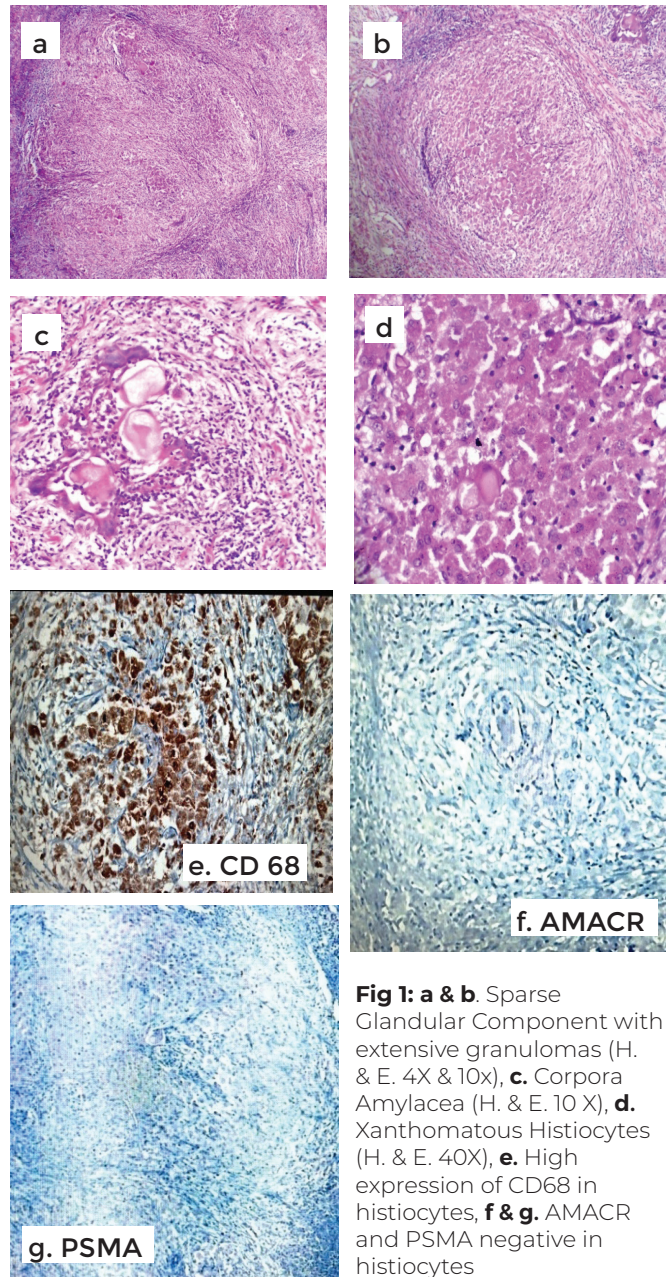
a & b. Sparse Glandular Component with extensive granulomas (H. & E. 4X & 10x), c. Corpora Amylacea (H. & E. 10 X), d. Xanthomatous Histiocytes (H. & E. 40X), e. High expression of CD68 in histiocytes, f & g. AMACR and PSMA negative in histiocytes
